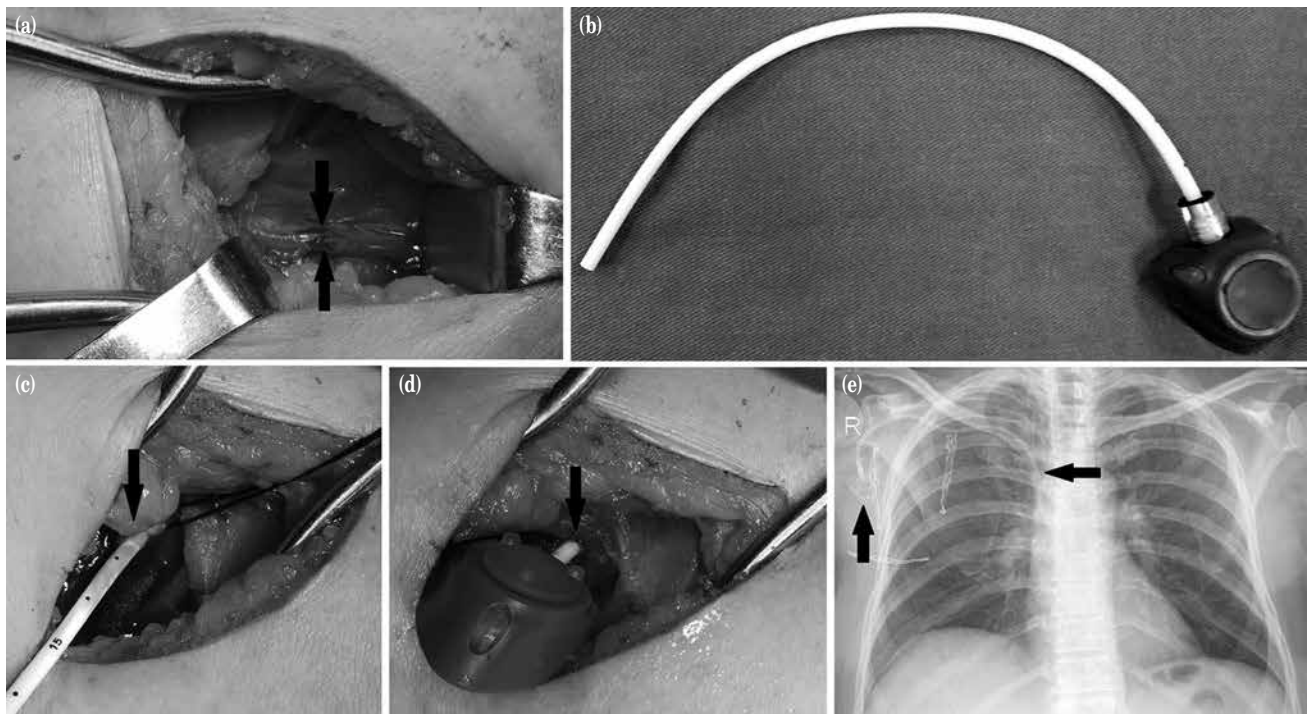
An external view of the right cephalic vein (a), connection of the port reservoir and the catheter (b), insertion of the totally implantable venous access port (TIVAP) through the right cephalic vein (c, d), black arrows showing the tip of the catheter and the port reservoir on chest X-ray image (e).
